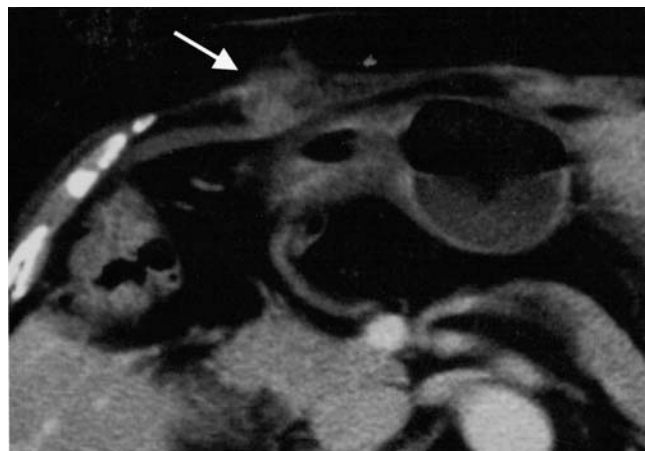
Case 4. CT showing a mass (*arrow*) in the right upper quadrant incision site 19 months after laparoscopic cholecystectomy (LC)
